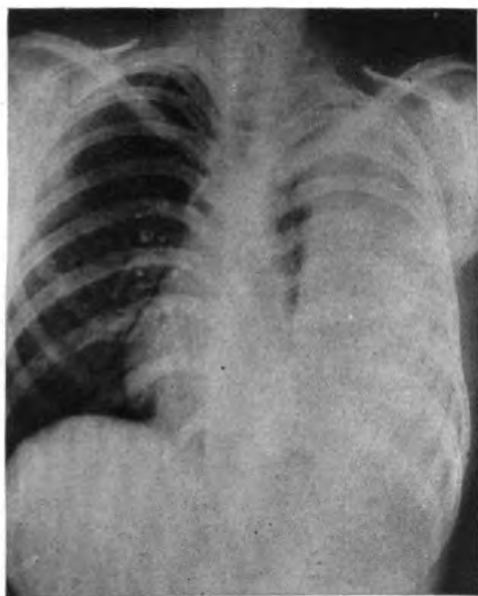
Case 5. Roentgenogram taken prior to operation. There is a massive fluid collection in the left hemithorax.*
